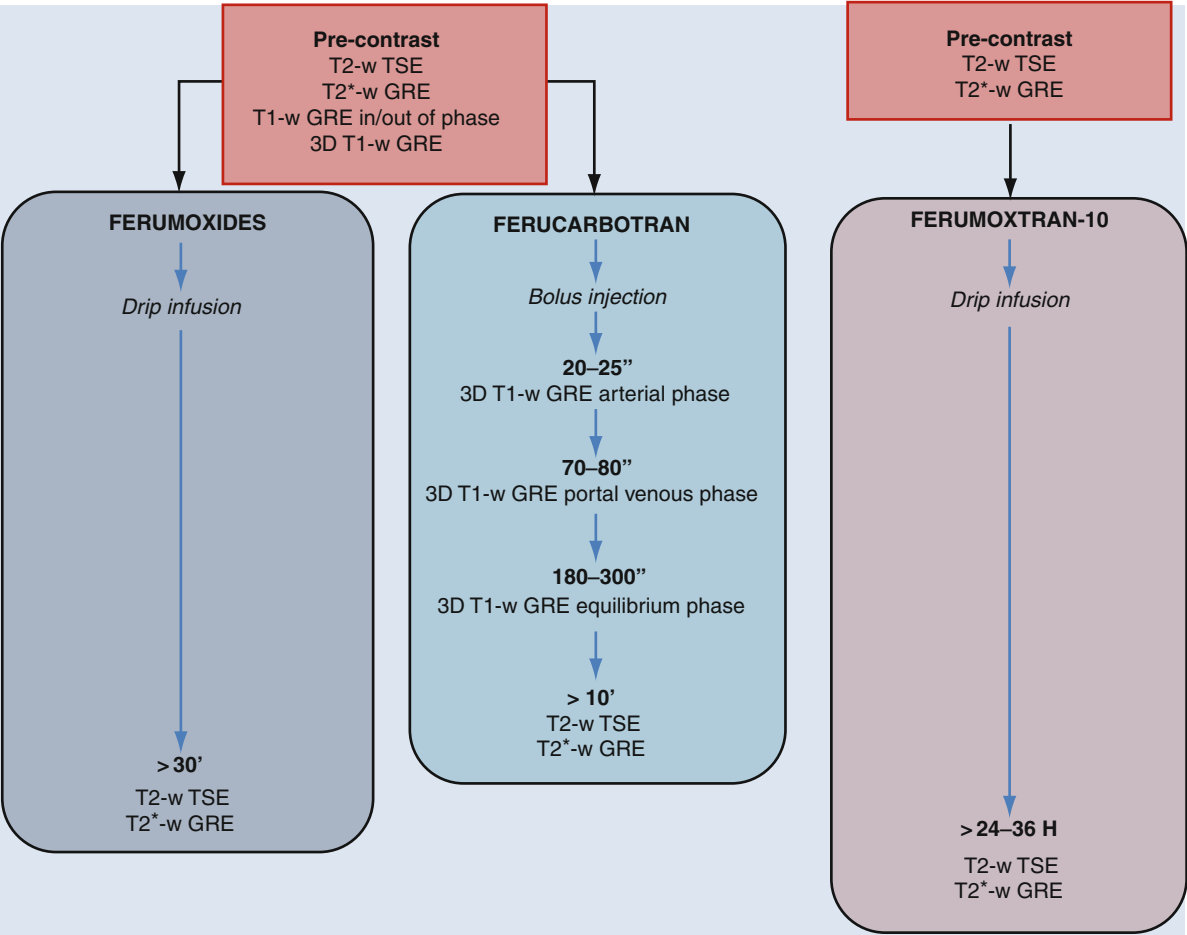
Imaging protocols for SPIO- and USPIO-enhanced MRI
